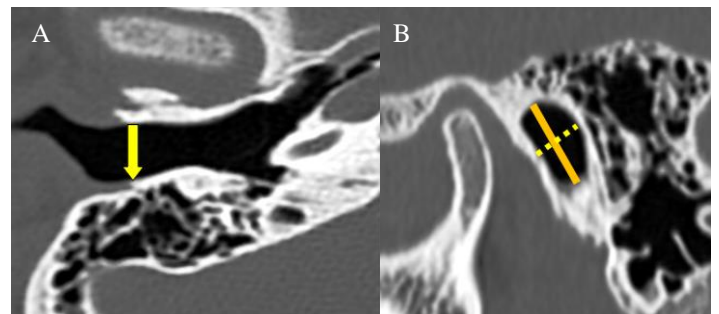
Axial CT images of the temporal bone. 3rd measurement point is at the level of the tympanomastoid suture (yellow arrow), 3B: Sagittal CT image of the temporal bone. Diameters at the level of the tympanomastoid suture (3a: non-interrupted line, 3b: interrupted line)
